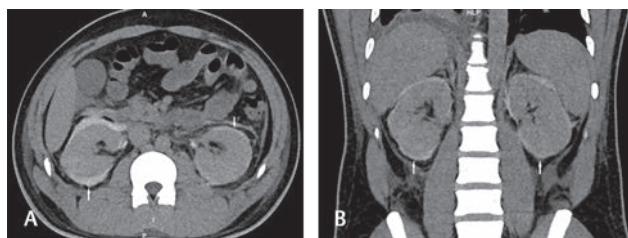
Axial (A) and coronal (B) images of computed tomography abdomen in excretory phase show the presence of contrast within the perinephric fluid (white arrows) on both sides.
